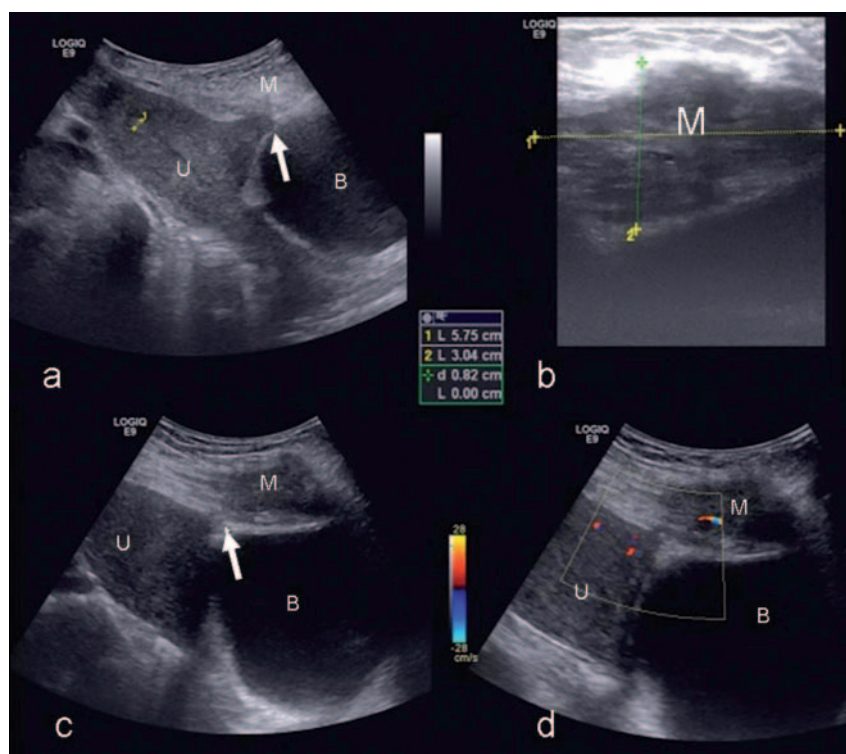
The same patient mentioned in Figure 2. The abdominal wall endometriosis lesion extending from the subcutaneous tissue to anterior wall of the uterus is detected by ultrasound. Potential gap from the defect of the anterior uterus wall to the endometrioma in the abdominal wall is indicated by a white arrow. M: abdominal wall endometrioma; U: uterus; B: bladder.
